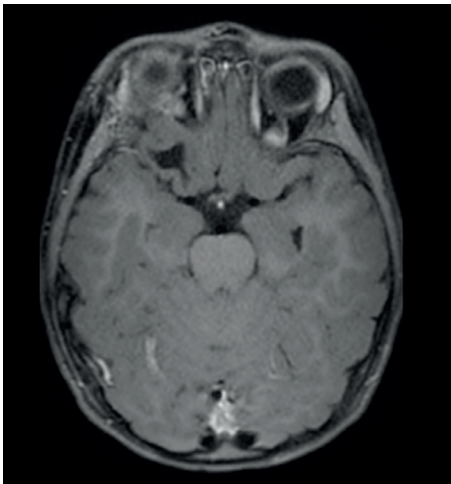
One year follow up of T1-weighted contrast of MRI of the brain (axial) showed no sign of remnant of tumor
